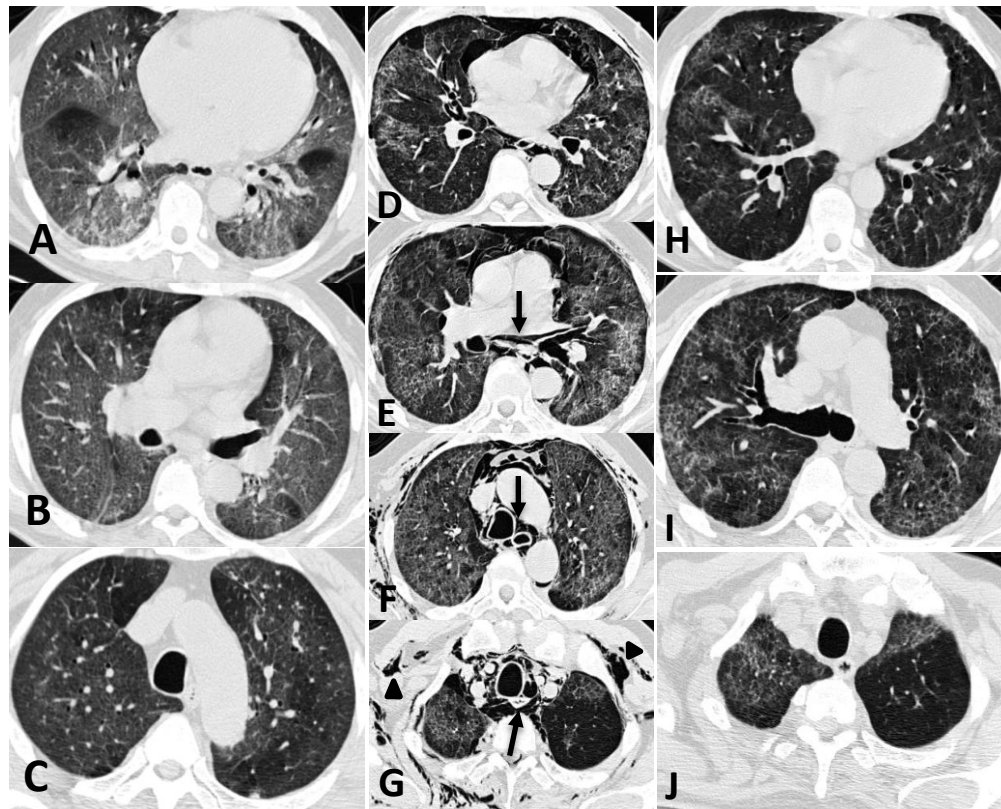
Axial images (A, B, C) of admission CT scan showing ground glass opacity. Axial images (D, E, F) on day 19th with the presence of pneumothorax, pneumomediastinum and subcutaneous emphysema. Axial images (H, I, J) at discharge with resolution of pneumothorax, pneumomediastinum and subcutaneous emphysema.
